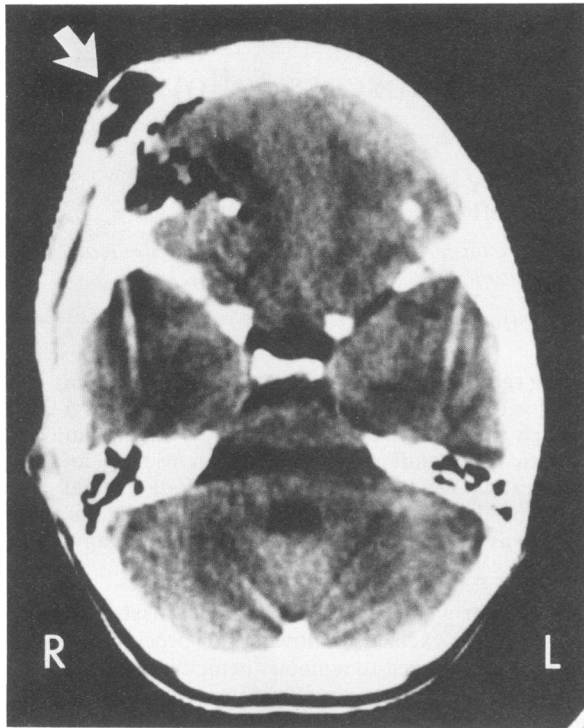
Cranial CT scan shows presence of air in frontal lobe and in soft tissues at dart entry site (arrow points to path of dart).
